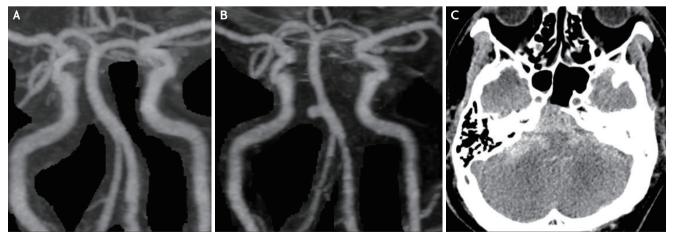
(A) CT angiography on the initial day. (B) CT angiography on the 12th day, showing a newly developed basilar artery pseudoaneurysm. (C) CT scan on the 12th day, revealing findings consistent with subarachnoid hemorrhage. CT, computed tomography.
